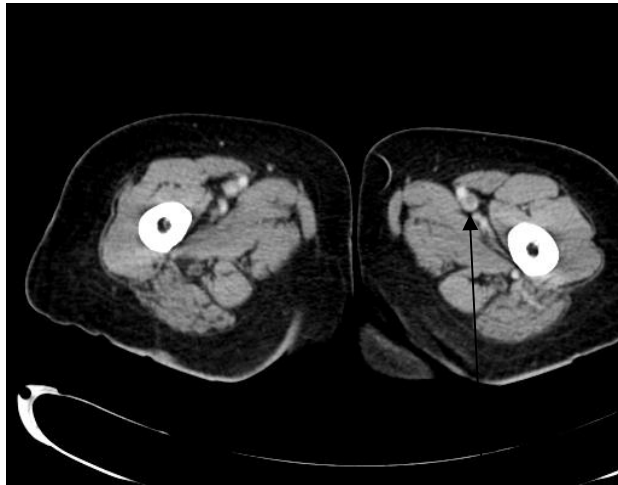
(c)CT venography axial view- DVT seen within the left superficial femoral vein(SFV) seen as a filling defect.
